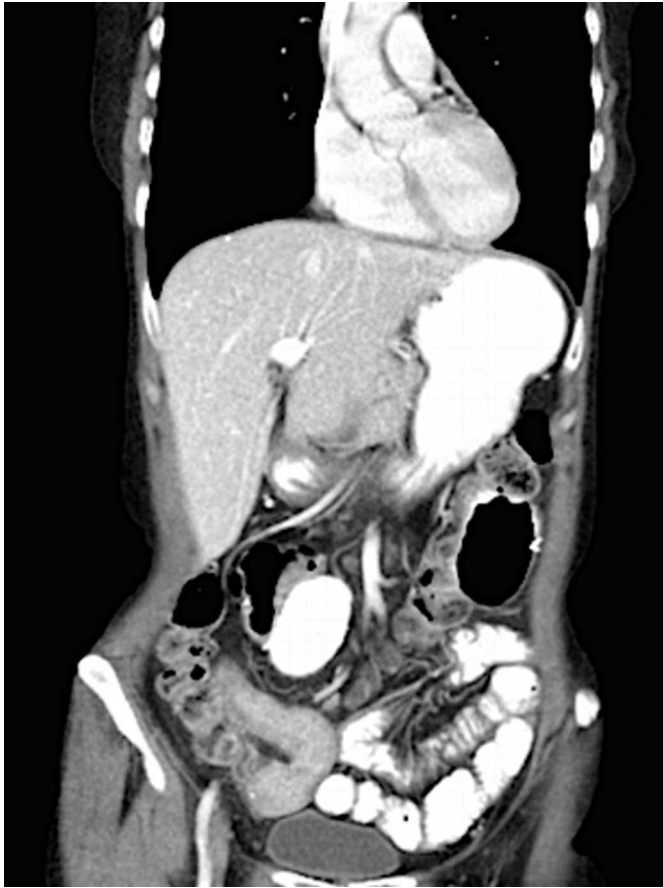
A representative photograph of a recent contrast-enhanced CT of the abdomen and pelvis. The distal small bowel demonstrates a significant amount of stricturing and some intestinal thickening.
